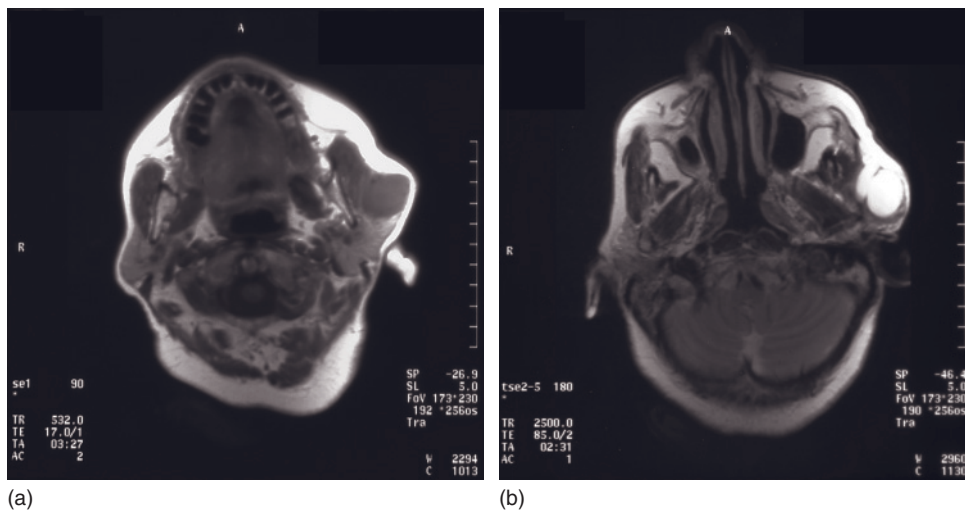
Magnetic resonance imaging scan of a patient with a superficial pleomorphic adenoma in the left parotid gland. On the T1-weighted image, the lesion has a low-to-intermediate signal (a), while on the T2 image, the lesion appears bright (b).
